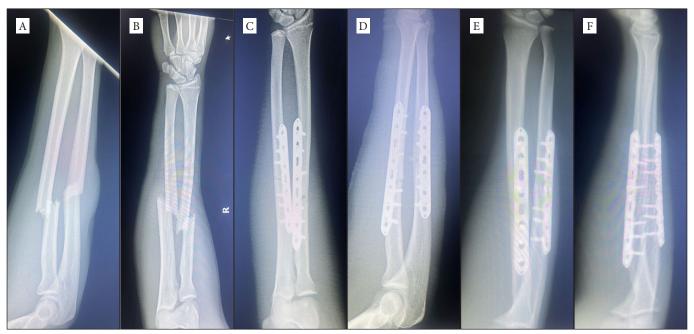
Preoperative posterior-anterior and lateral radiographs of a 34-year-old male patient who underwent plate osteosynthesis due to right diaphyseal forearm fracture (A, B); postoperative posterior-anterior and lateral radiographs at 2 weeks (C, D); postoperative posterior-anterior and lateral radiographs at 12 months (E, F).
